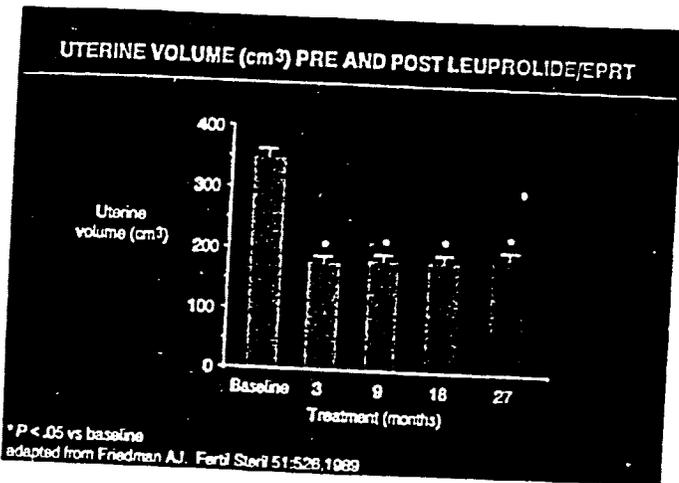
Impact of a non-concurrent oestrogen/progestin 'add-back' regimen on sonographically monitored uterine volume. Adapted from Friedman (1989).
